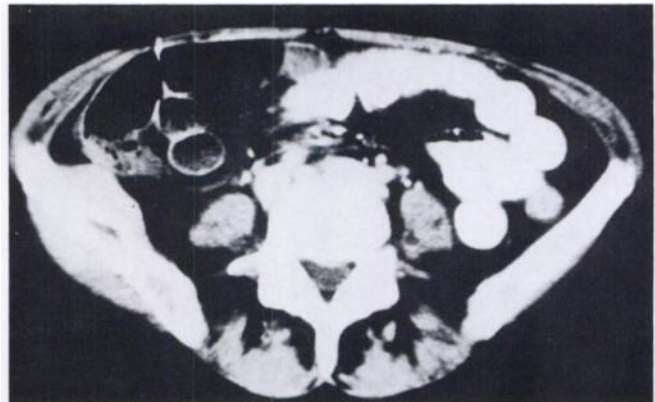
CT of the pelvis showing a destructive lesion in the right iliac bone. Note the pronounced enhancement after contrast administration.
